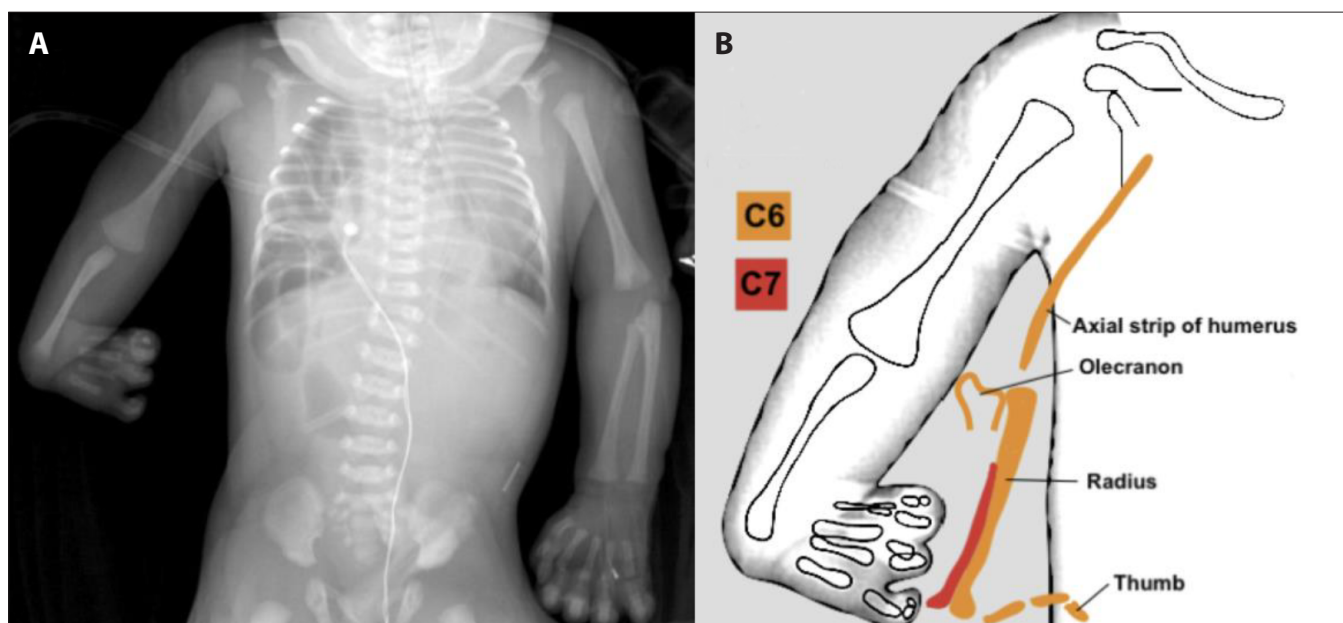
Radiograph demonstrating right-sided congenital diaphragmatic hernia with an ipsilateral upper limb-reduction defect (reduced width of humeral shaft with flattened, flared distal end, shortened ulna with absence of the olecranon, absent radius, and an absent thumb). Pre-axial polydactyly on the left. Situs inversus of the liver is visible. Additional abnormalities of the ribs and vertebrae are present: thirteen ribs are well discerned on both the right and left, but mal-aligned and not symmetrically paired at all levels. The left-sided ribs start two vertebral levels above the right. Right side: Of the well-discerned ribs on the right, the first two are mildly hypoplastic compared with the corresponding ribs at the same level on the left, and the third is very hypoplastic as there is a corresponding hemivertebra on the left. The fourth rib is broad and the fifth is mildly hypoplastic. The fourth and fifth ribs both converge towards one vertebra. The sixth rib is located between two vertebrae. The eighth and ninth rib articulations with the vertebra are not well seen on the radiograph but appear to lead towards their respective vertebrae. Possible partial fusion of the right aspect of the vertebrae at the articulation of the twelfth and thirteenth ribs. Left side: The fifth rib arises off a hemivertebra. The eighth and ninth ribs are each located between two vertebrae.
